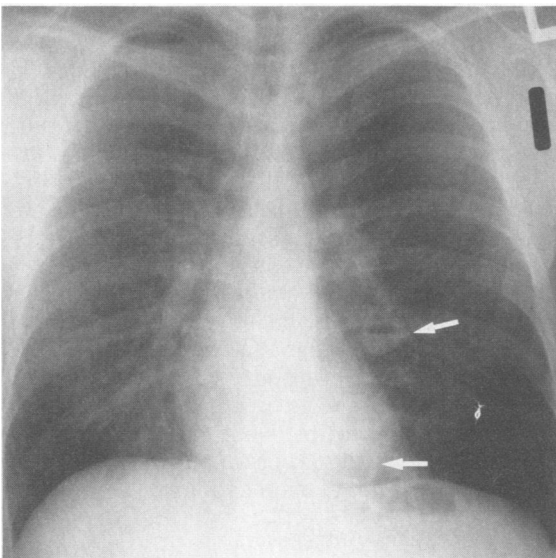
A posteroanterior chest radiograph shows two cavitary lesions (arrows), one with an air-fluid level, in the lower left hemithorax. The left lower lobe is more radiolucent than the right.
